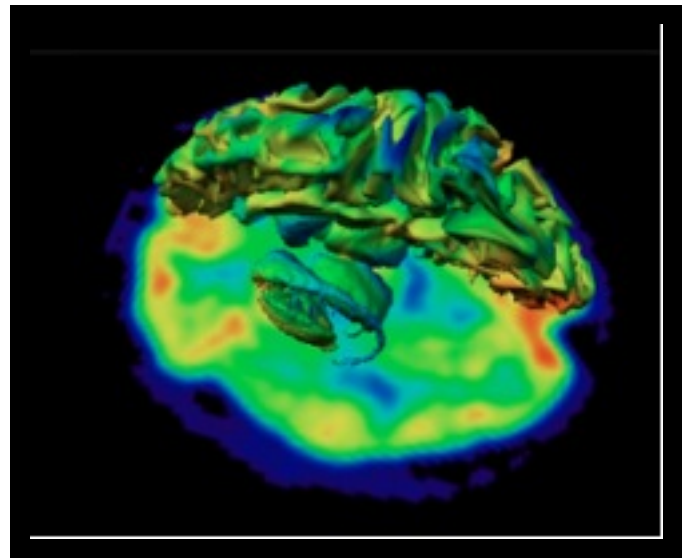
Volumetric embedded brain structure visualization in an axial PET fluorodeoxyglucose (FDG) section. Notice the contribution of three-dimensional models that aid in the interpretation of areas affected by different brain activation levels, improving the complex functional imaging interpretation.
